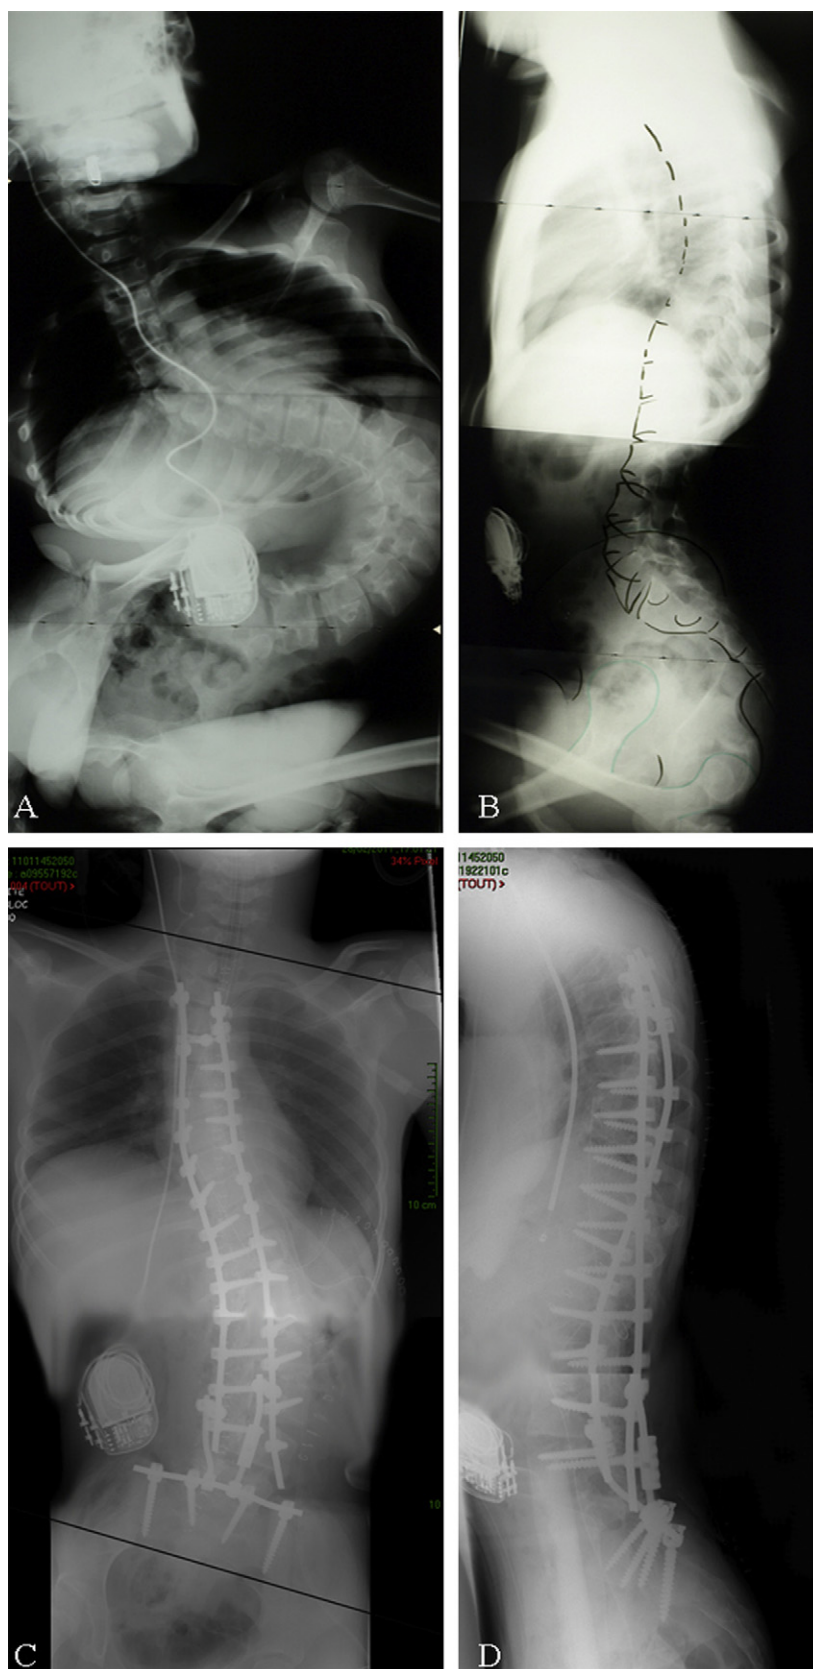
Severely evolved spinal deformity in a 15-year-old boy with cerebral palsy and spastic quadriplegia. A and B. Preoperative X-rays. C and D. Postoperative X-rays after anterior release of lumbar scoliosis convexity and posterior osteosynthesis. Despite initial severity, overall trunk, shoulder line and seated pelvis alignment is satisfactory.
